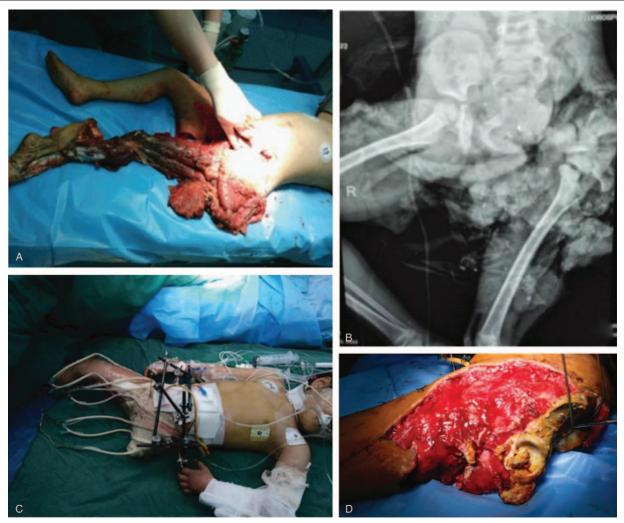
(A) Intraoperative view of the abdominal wall, the gluteal region, and the leg. (B) Admission pelvic anteroposterior X-ray showing the dislocation of the left sacroiliac joint, diastasis of the pubic symphysis. (C) Intraoperative view of a following Ilizarov application and wound management. (D) View of new granulation generated on the surface of the peritoneum in the 3rd debridement.
